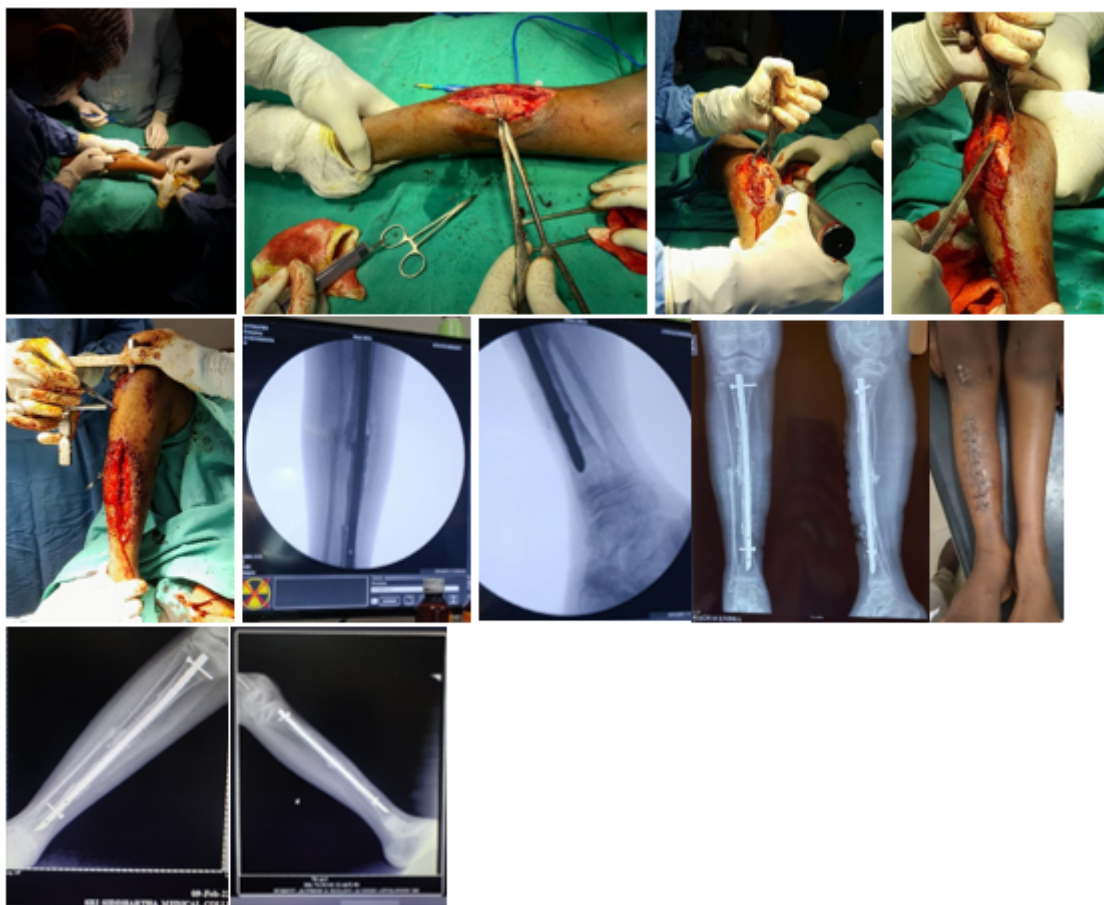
6 weeks follow up x-rays showing fracture union in progress
